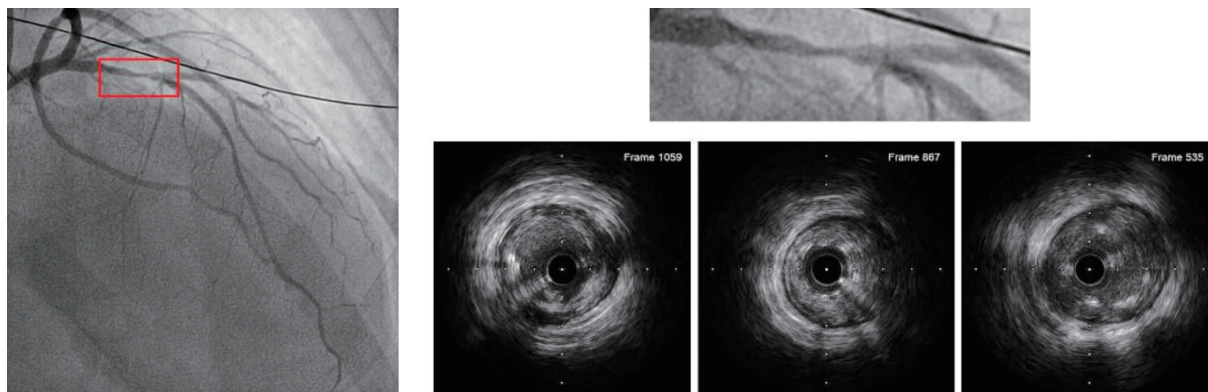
Initial angiography (left). Intravascular ultrasound of the proximal, middle and distal region of the LAD lesion (right).
